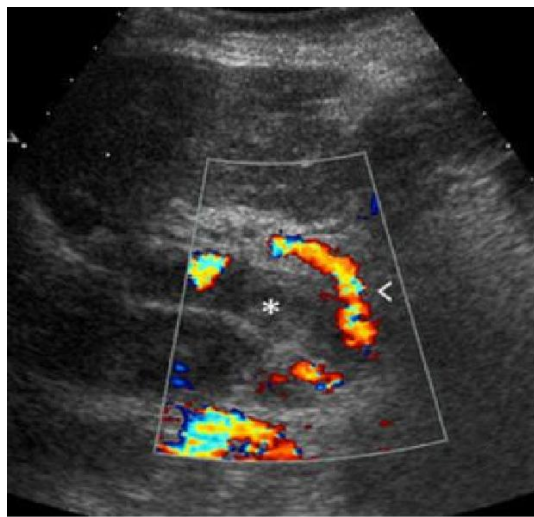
Echo-Doppler showing a 22 mm portal vein with echogenic material completely obstructing its lumen, findings consistent with a portal vein thrombosis.
